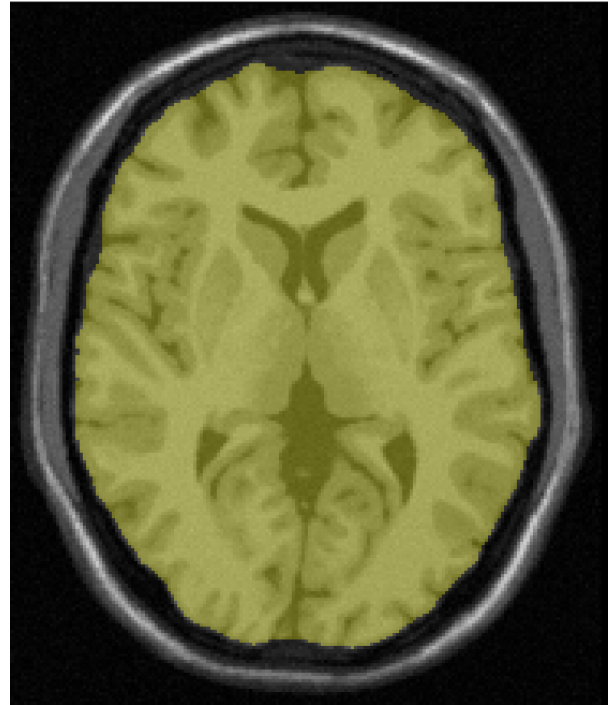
Axial slice of T1-weighted image. The yellow label contains the brain after skull stripping.
